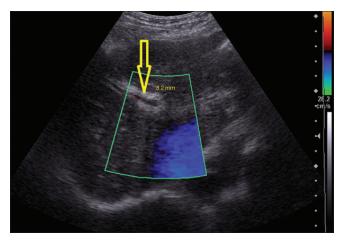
Ultrasound examination, showing in longitudinal reconstruction, hyperechoic thickening; in band parallel of the port trunk and the color signal in the lumen of the vessel in Doppler determine an permeability, Stage 3
